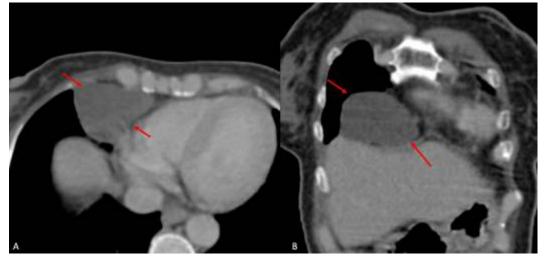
(A, B): Axial (A) and coronal (B) CT scan images show a cyst (nonenhancing and thin, imperceptible walls), consistent with a pleuropericardial cyst.
